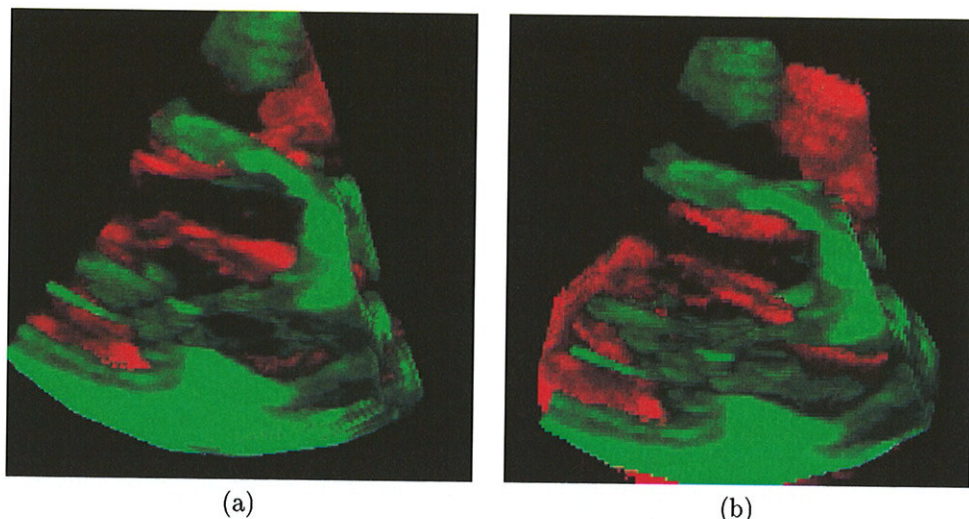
Volume rendering of the left ventricle from a transthoracic acquisition. Green is end-diastole, and red is late systole. (a) No compensation. (b) With axis compensation.
